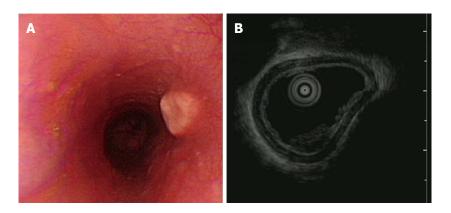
Granular cell tumor. A: Granular cell tumor is endoscopically recognized as a firm, yellowish subepithelial tumor covered with the normal mucosa in the esophagus; B: Endoscopic ultrasonography of granular cell tumor shows a homogenous hypo-echogenic tumor extending from the muscularis mucosa layer, and the musculais propria is not involved.
